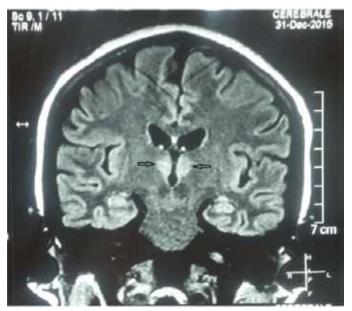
FLAIR coronal images signal-intensity alterations with different intensity patterns are seen in the thalami, signal-intensity alterations in the mammillary bodies.
